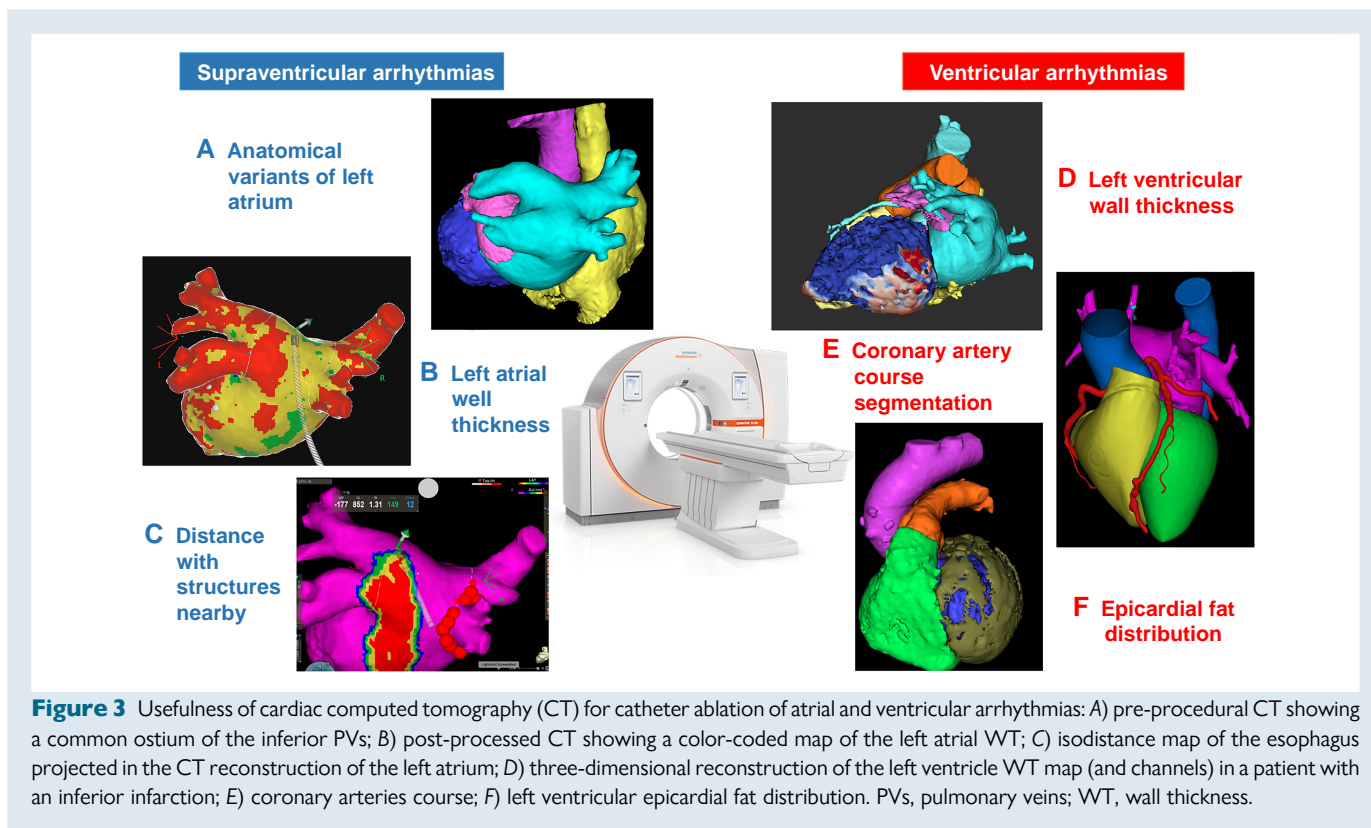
Usefulness of cardiac computed tomography (CT) for catheter ablation of atrial and ventricular arrhythmias: A) pre-procedural CT showing a common ostium of the inferior PVs; B) post-processed CT showing a color-coded map of the left atrial WT; C) isodistance map of the esophagus projected in the CT reconstruction of the left atrium; D) three-dimensional reconstruction of the left ventricle WT map (and channels) in a patient with an inferior infarction; E) coronary arteries course; F) left ventricular epicardial fat distribution. PVs, pulmonary veins; WT, wall thickness.
